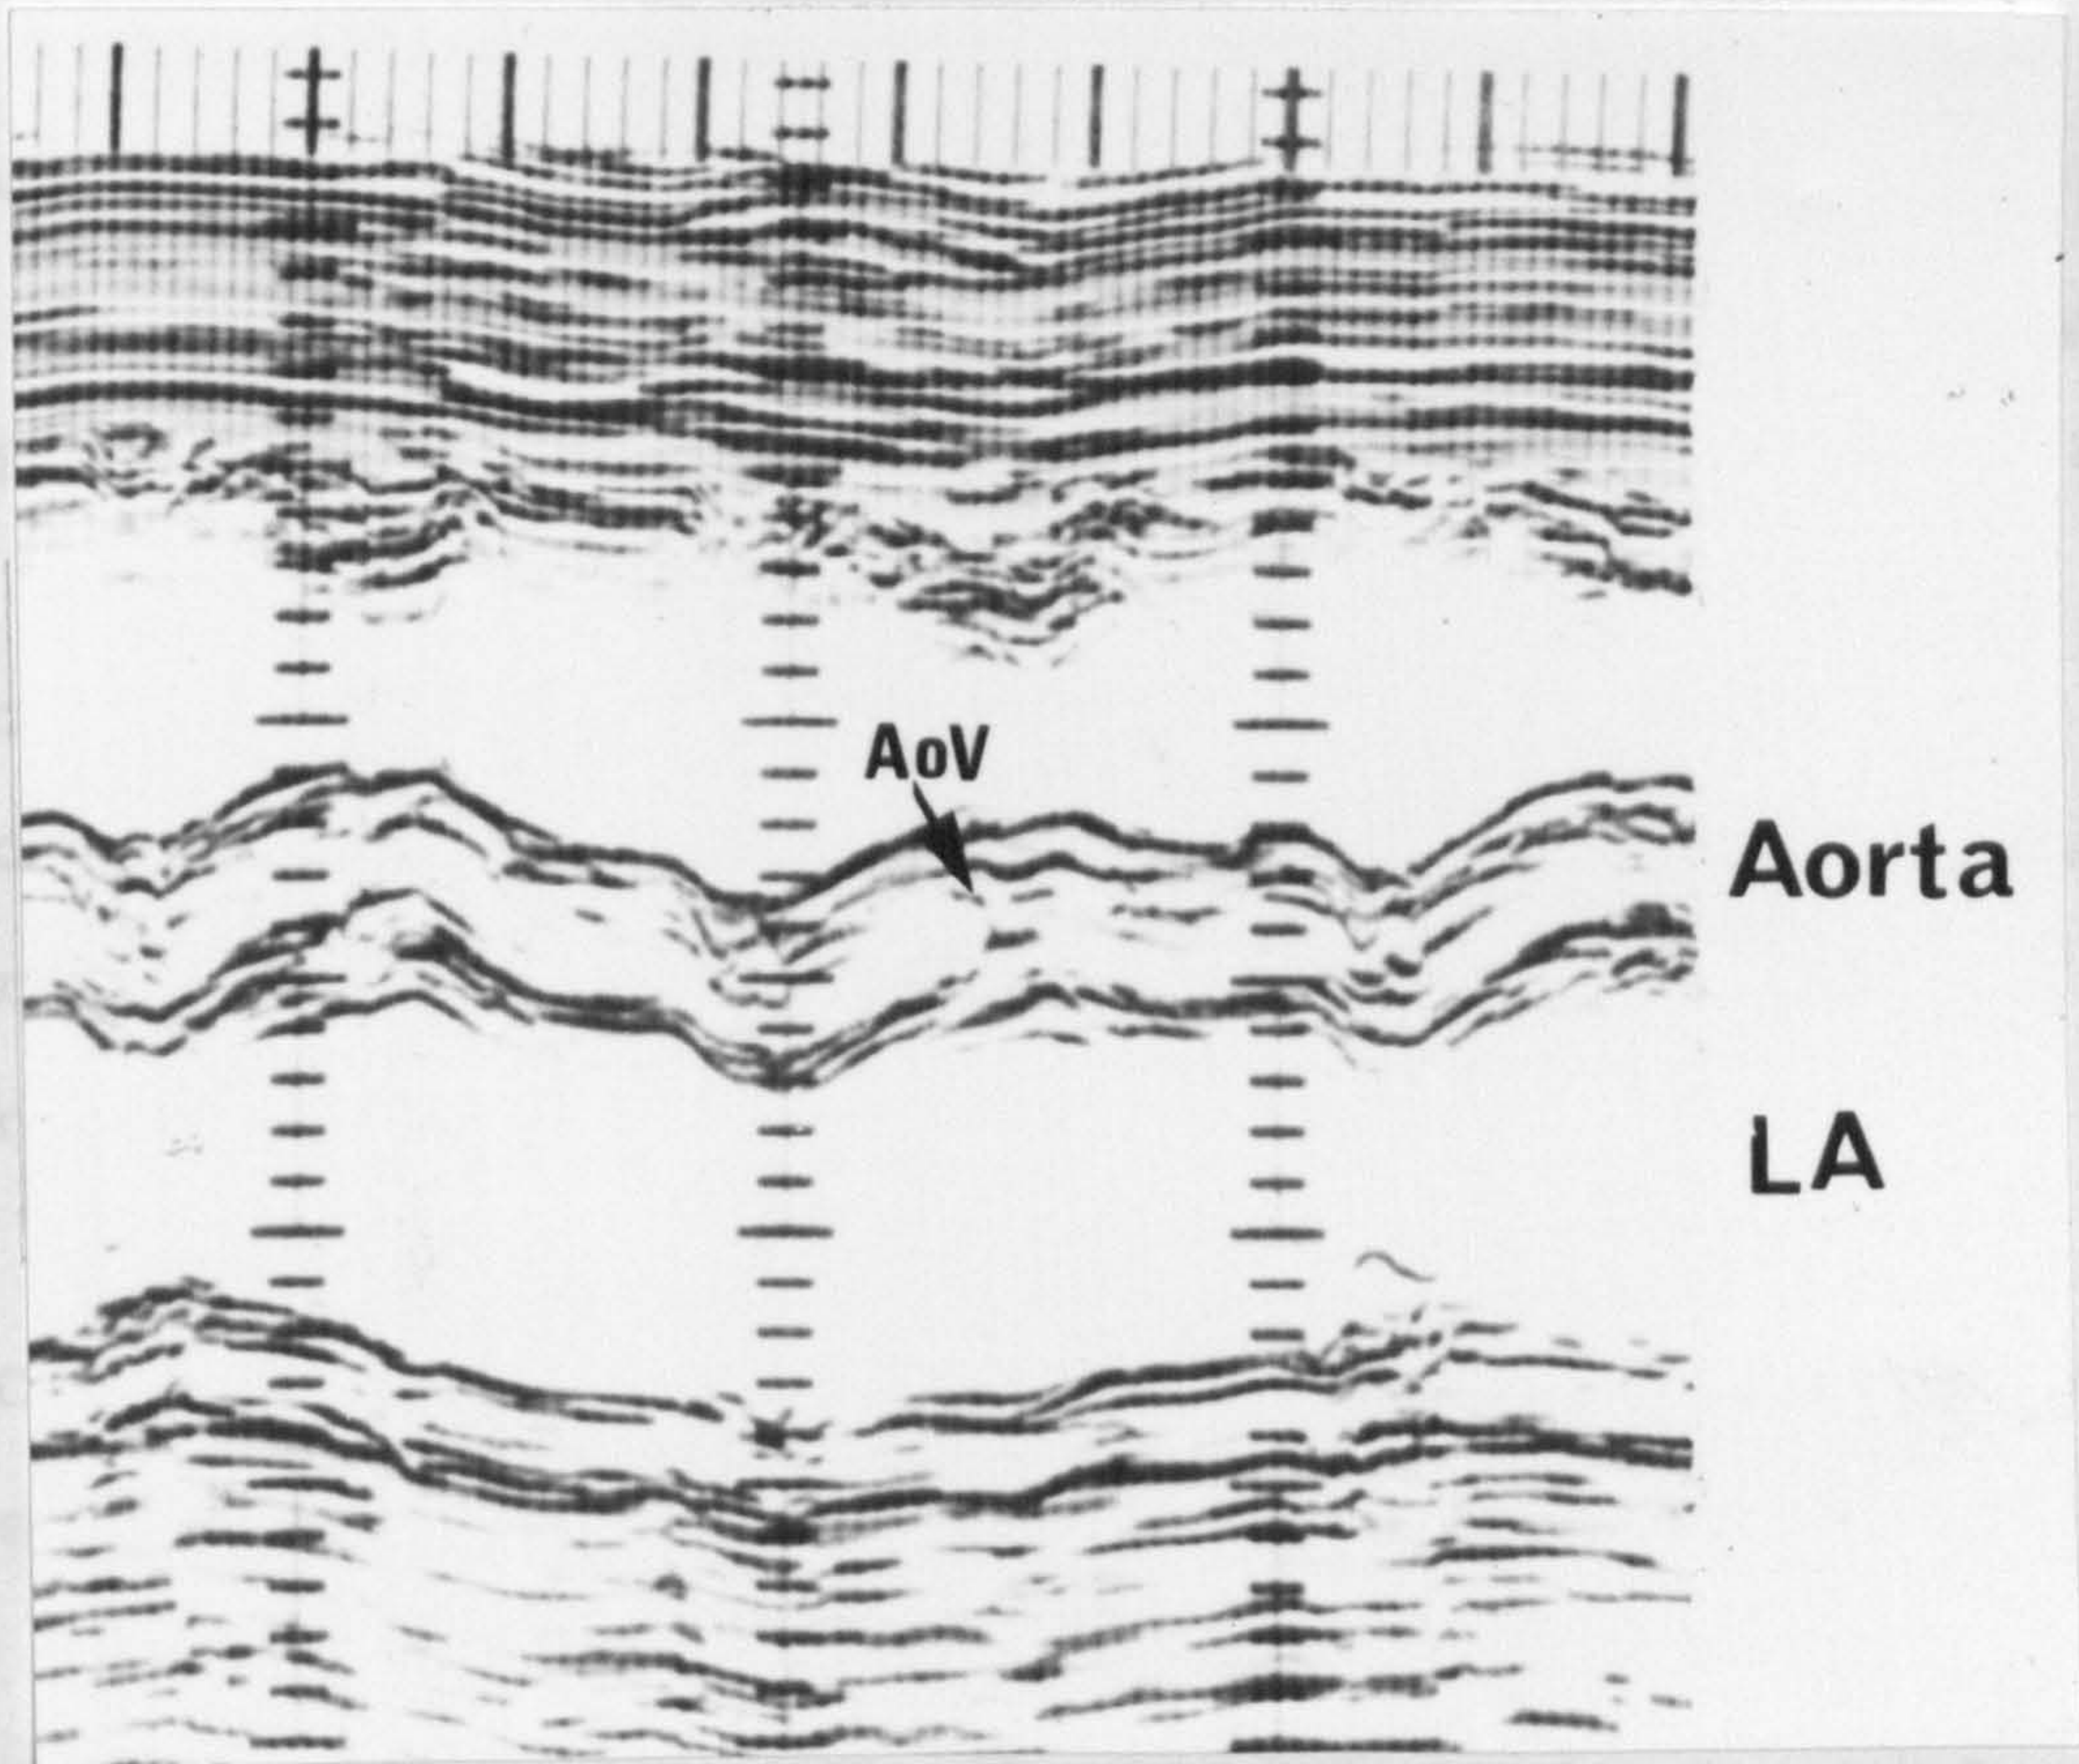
The M mode echocardiogram in Case 5. The aorta has a lumen and contains a valve which can be seen to open. The aortic root size is smaller than normal for this gestational age at 0.6 cms. The left atrium is dilated at 1.6 cms.
